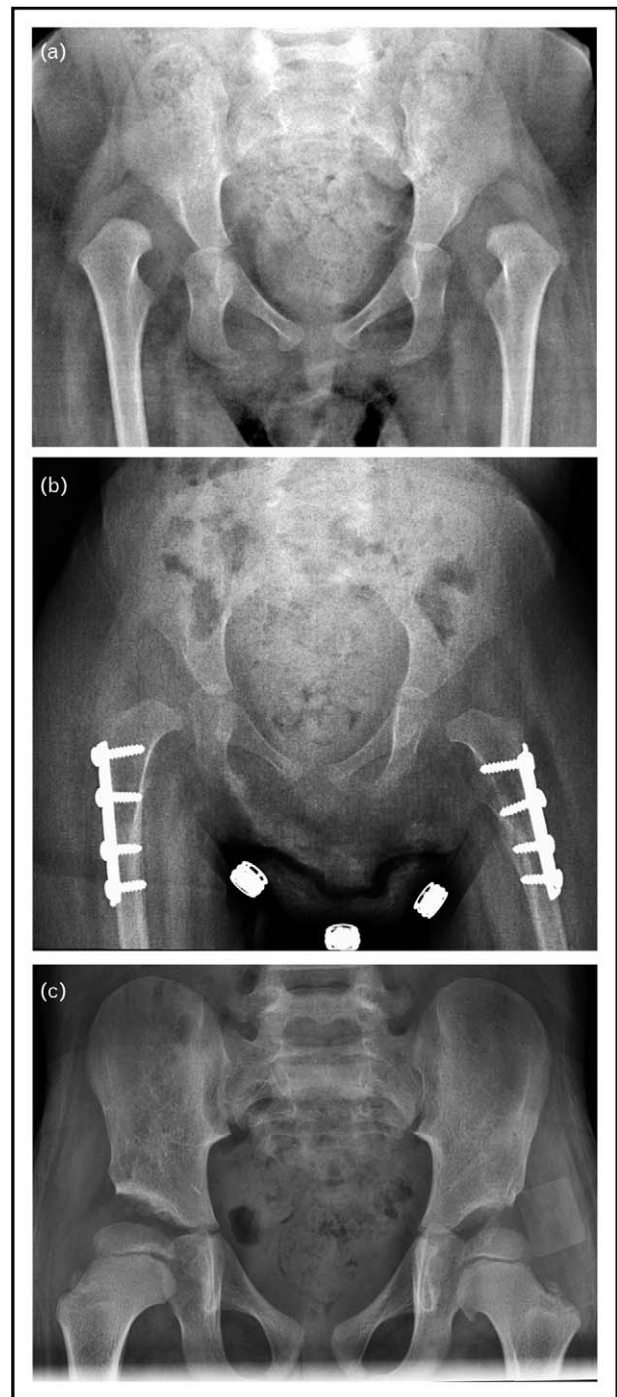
Twenty-month-old boy with arthrogryposis, with bilateral hip dislocations: (a) Anteroposterior (AP) pelvis radiograph preoperatively, demonstrating bilateral hip dislocations; (b) AP pelvis radiograph following bilateral hip open reduction with ligamentum teres tethering of the femoral head, and bilateral femoral shortening osteotomies; (c) follow-up AP pelvis radiograph at 6 years of age. The patient ambulates independently.
